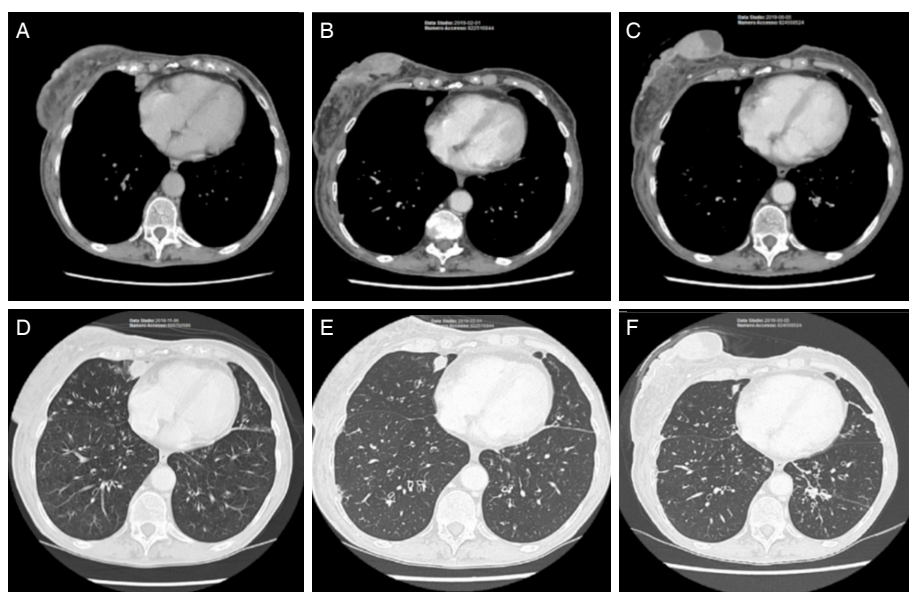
CT scan presentation and clinical course of local and metastatic lesions during chemo-immunotherapy with cyclophosphamide, fluorouracil and interleukin-2 and salvage carboplatin, paclitaxel \pm capecitabine regimen. A: neoplastic masses of 19 mm \times 13 mm to the infero-lateral quadrant and 40 mm \times 35 mm to the medial quadrant of the right breast. Metastatic lesion of 11 mm \times 25 mm to the middle lung lobe anteriorly (November 2018); B: dimensional increase of the heterogeneous lesion localized in the right central breast of 63 mm \times 34 mm, with current ulcerative aspects of the overlying skin after chemo-immunotherapy (February 2019); C: partial reduction of density due to necrosis and size of the polylobed and ulcerated neoplastic mass of 7 cm located in the right breast after salvage chemotherapy (June 2019); D: metastatic lesion of 11 mm \times 25 mm to the middle lung lobe anteriorly (November 2018); E: reduction in size of metastatic lesion of 11 mm \times 7 mm to the middle lung lobe anteriorly after chemo-immunotherapy (February 2019); F: further reduction in size of metastatic lesion of 10 mm \times 6 mm to the middle lung lobe anteriorly after salvage chemotherapy (June 2019)
